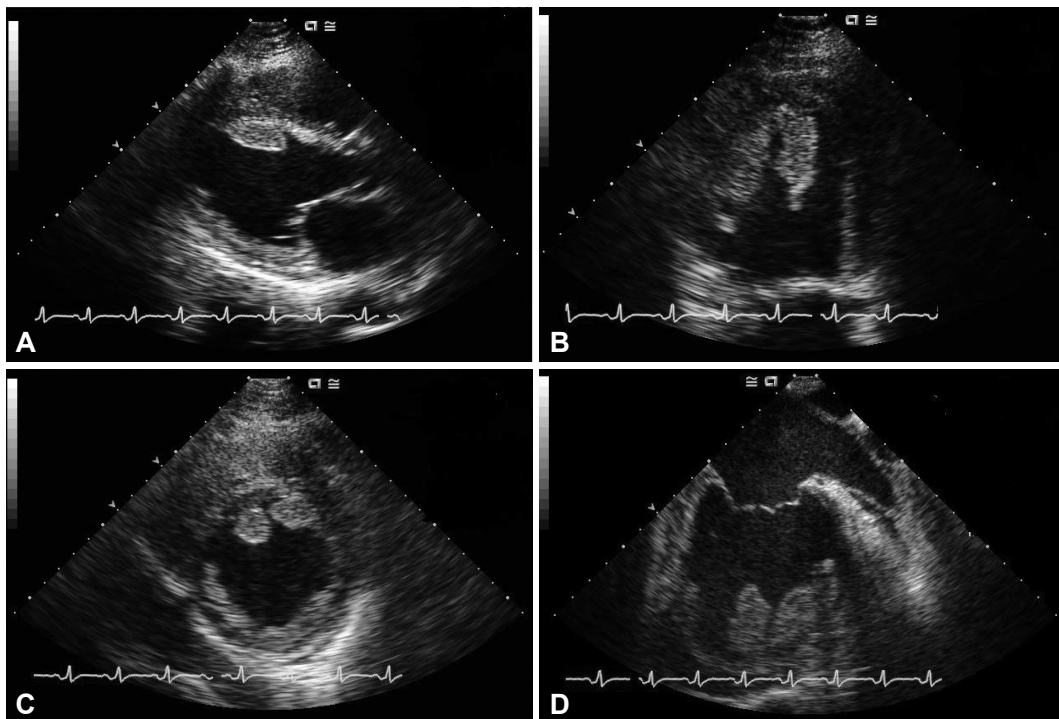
Initial transthoracic (A, B and C) and transesophageal (D) echocardiograms show severe LV systolic dysfunction and dilatation with multiple, pedunculated thrombi attached to LV apical wall. LV: left ventricle.
